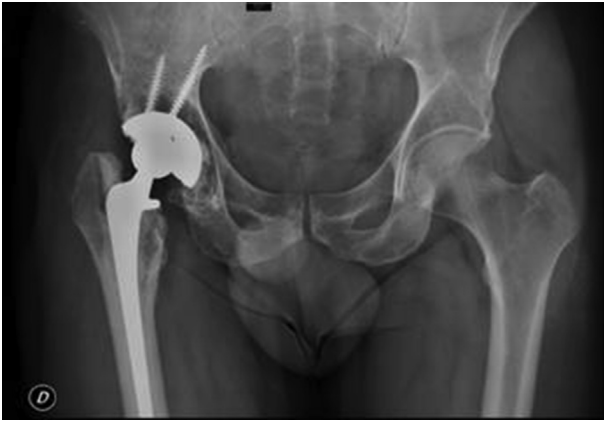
Pelvic x-ray film performed 96 months postoperatively shows revision shell cup fixed with screws. Radiolucent lines are present in zone 2 and 3. Patient did not refer for any discomfort.
